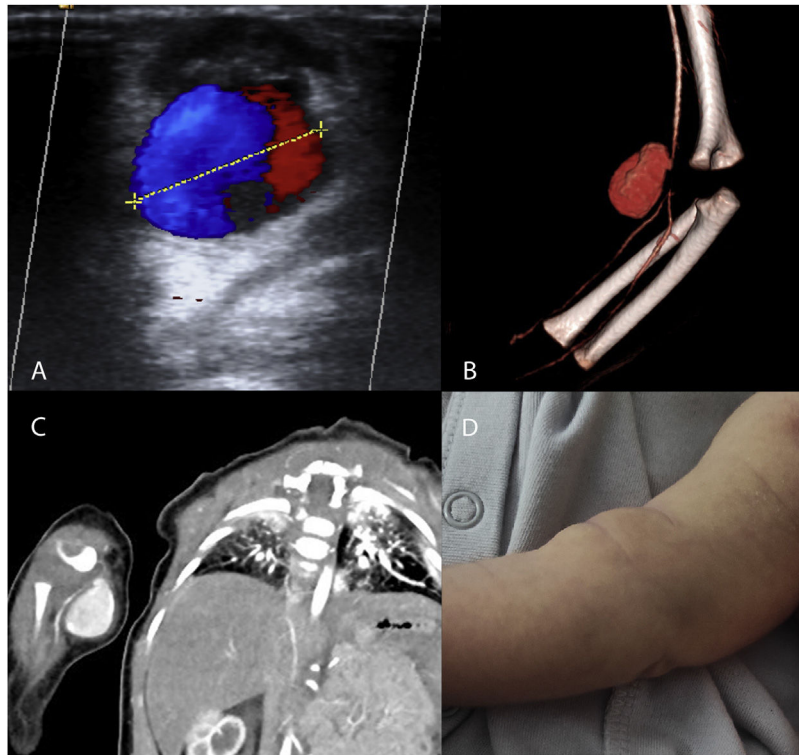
(A–C) Imaging studies of patients with pseudoaneurysms. (A) Doppler ultrasound. Yin–yang sign attributed to turbulent flow inside the arterial pseudoaneurysm. (B, C) CTA and 3D reconstruction of pseudoaneurysm dependent on the right brachial artery, with distal narrowing of vessel calibre. (D) Photograph of the patient with a pseudoaneurysm in the right brachial artery. Mass in right forearm 48h after the traumatic puncture.
